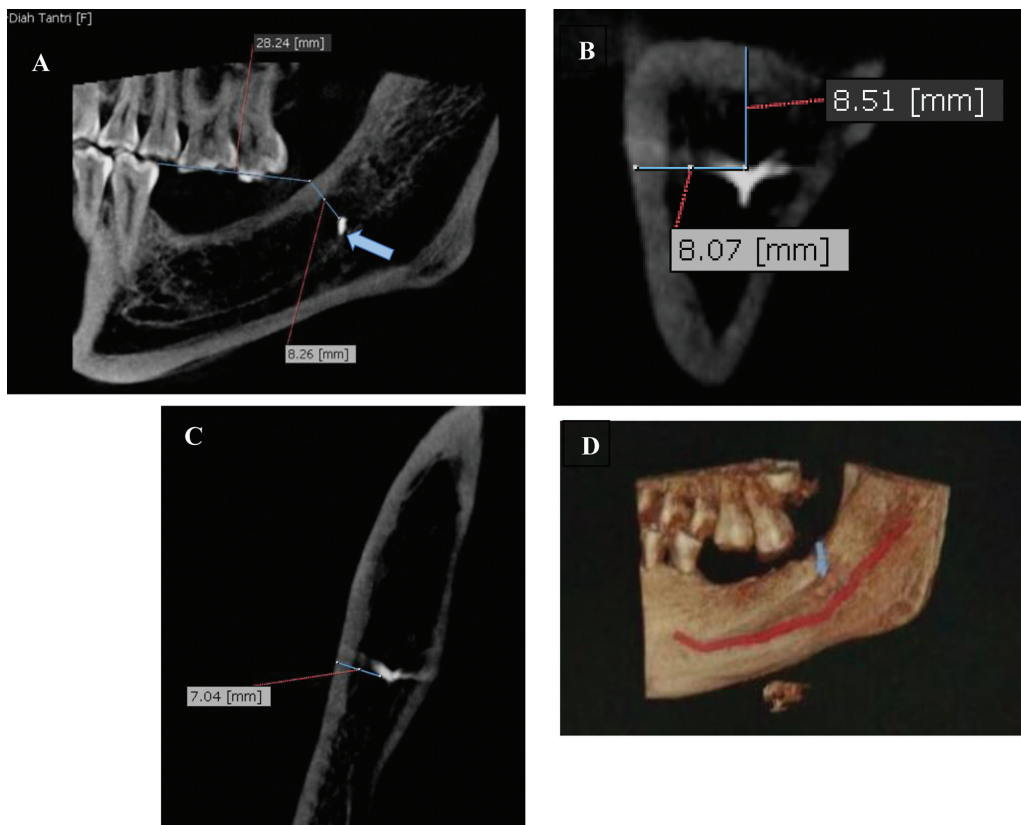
Result of cone beam computed tomography (CBCT) scan. (A) Sagittal view. (B) Coronal view. (C) Axial view. (D) Three-dimensional (3D) reconstruction buccal view.
